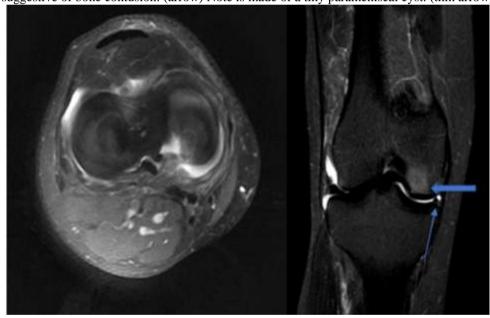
MRI left knee in a 30yr old patient following trauma. Axial and coronal PD-FS images show radial tear of medial meniscus with knee joint effusion. Hyperintense signal is seen involving lateral condyle of femur suggestive of bone contusion. (arrow) Note is made of a tiny parameniscal cyst. (thin arrow)
